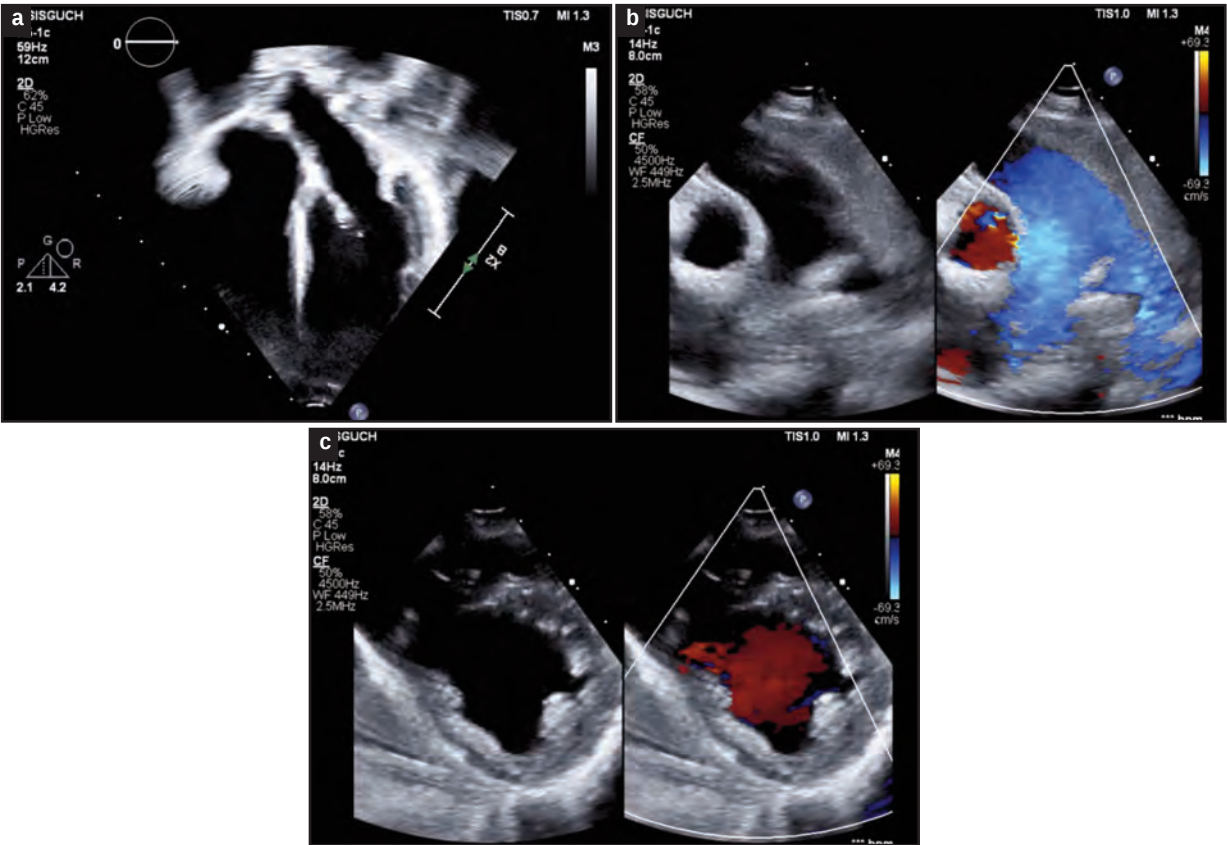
Post-treatment Echocardiogram; (a,b) Right ventricle and pulmonary artery were much less dilated (c) Restored circular left ventricle
